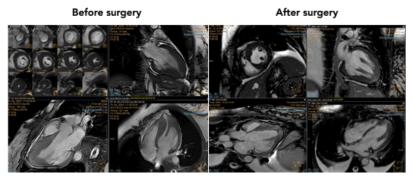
Cardiac MRI before and 12 months after apical myectomy
